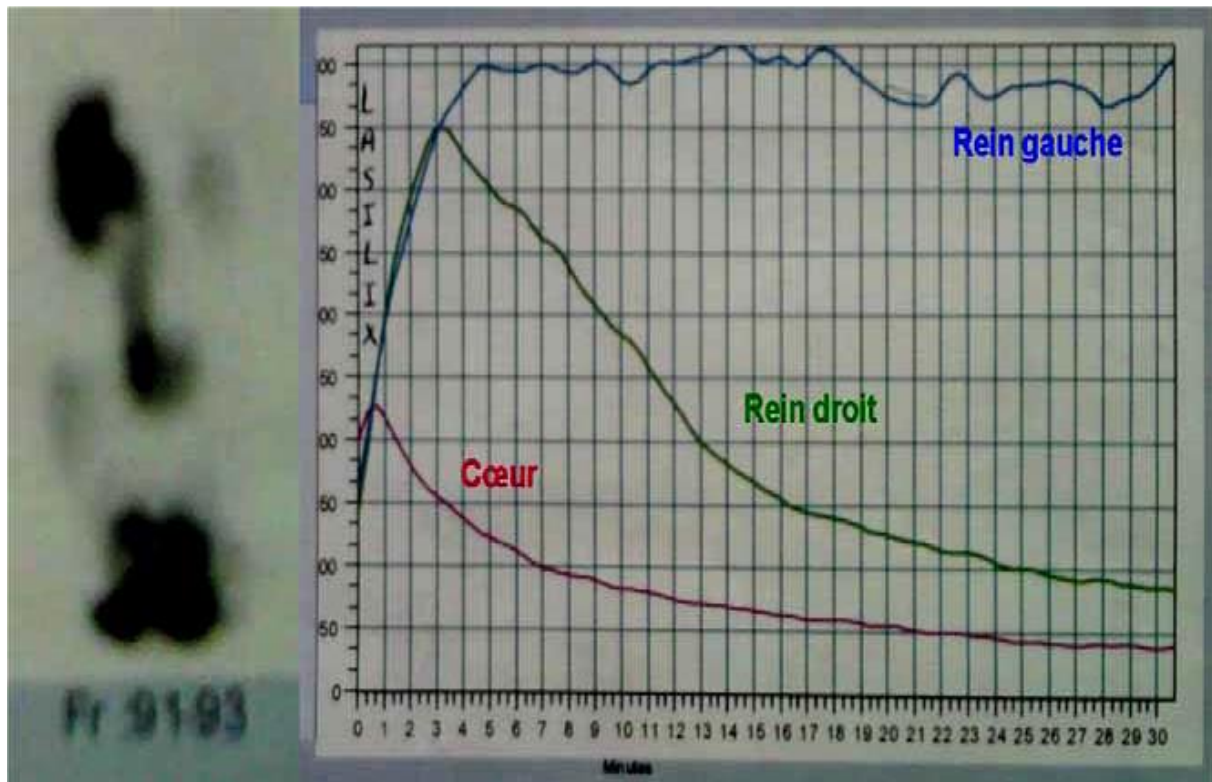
renal scintigraphy (left obstructive ureteropyelocal stasis).
